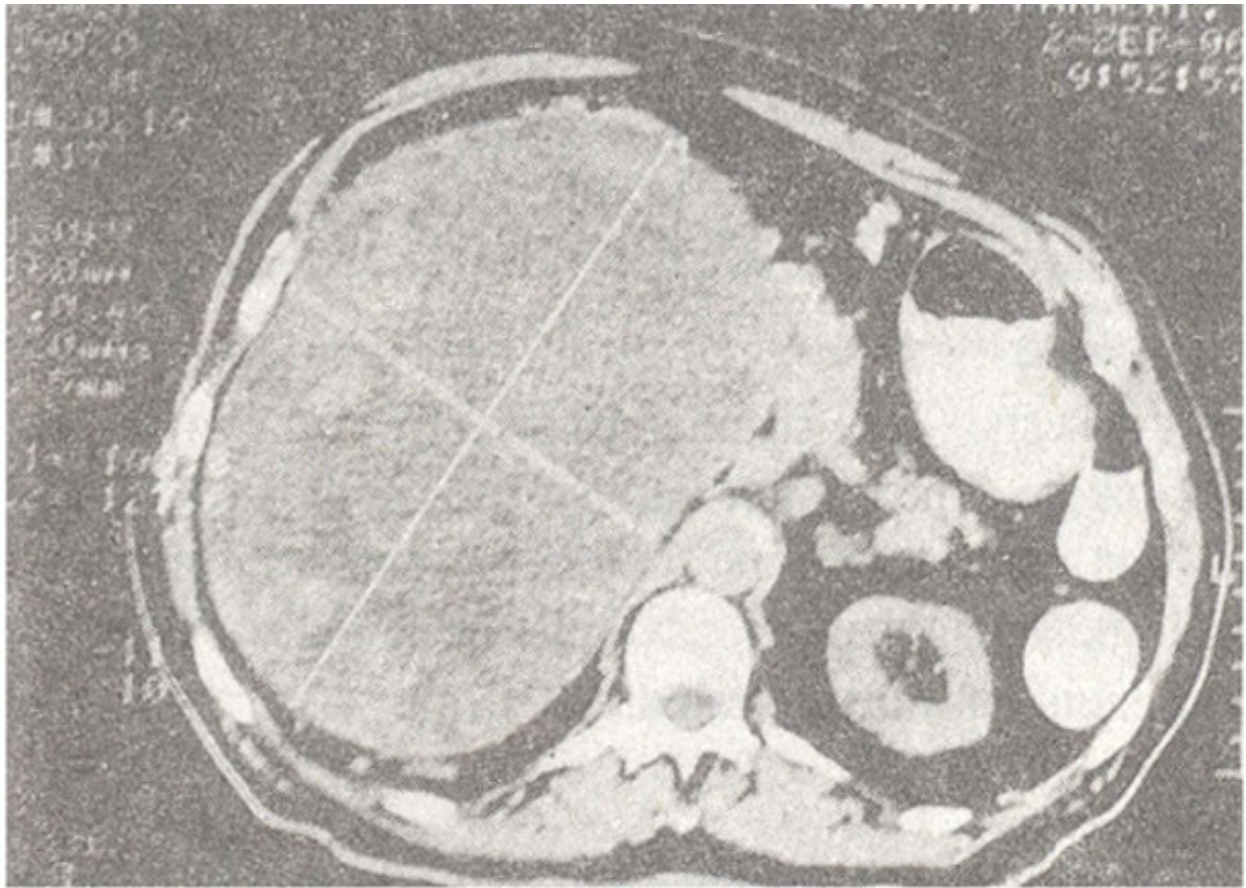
CT scan showing a huge mass arising from right kidney, part of the kidney is visible too. There is no evidence of lymphadenopathy, great vessels are displaced to the opposite side.
